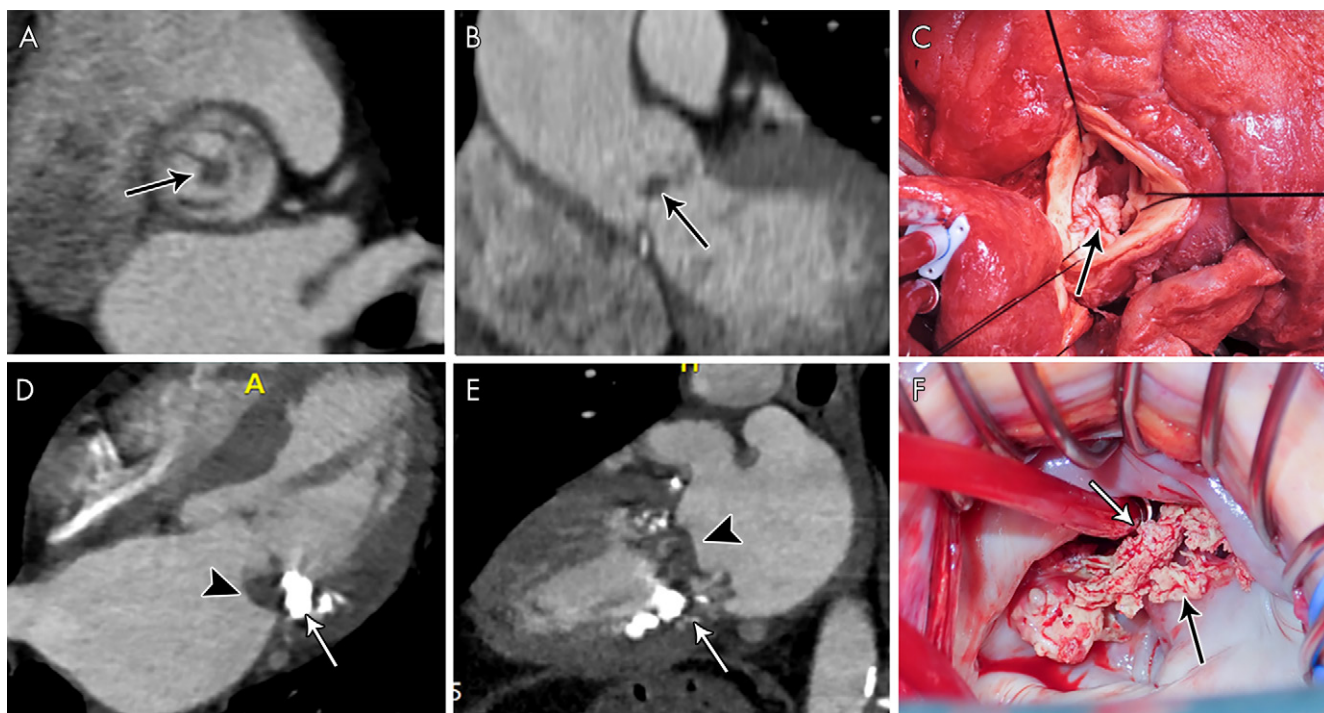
A, Short-axis and, B, oblique coronal contrast-enhanced CT images of the aortic valve in a 59-year-old man with a history of aortic valve replacement who presented with fever and stroke, concerning for infective endocarditis (IE). Images show a nodular attenuation (arrows, approximately 6 mm) along the prosthetic leaflet, suggesting vegetation. C, Intraoperative image in a 34-year-old man shows native aortic valve vegetations (arrow). D, Four-chamber and, E, two-chamber contrast-enhanced CT images in a 72-year-old woman suspected of having IE show severe mitral annular calcification (arrows) and ill-defined hypoattenuation (arrowheads) predominantly along the posterior mitral valve leaflet and the posterior mitral annulus compatible with vegetations. F, Intraoperative image in a 51-year-old man shows native mitral valve vegetations (arrows).
